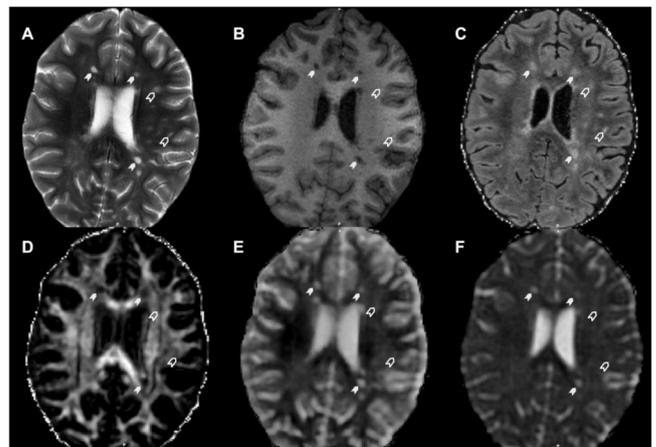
Conventional and Advanced MRI sequences for MS lesions. (A) T2WI (B) T1WI (C) FLAIR (D) DTI-FA (E) qMM (F) DTI-RD. Images acquired from a RRMS patient showing lesions in different evolution stages. Filled arrows = demyelinating lesions with hypointense T1WI signal. Empty arrows indicate demyelinating lesions with partial remyelination signal.
